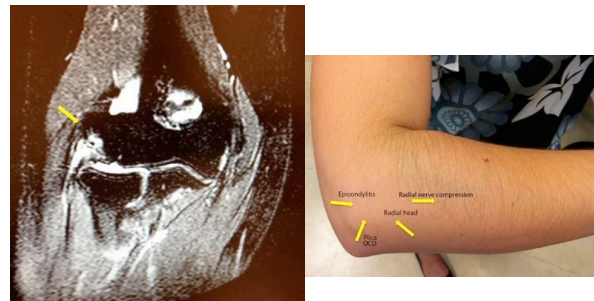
Coronal T-2 weighted MRI image of a right elbow showing an injury of the insertion of the extensor muscles at the lateral sided elbow .
